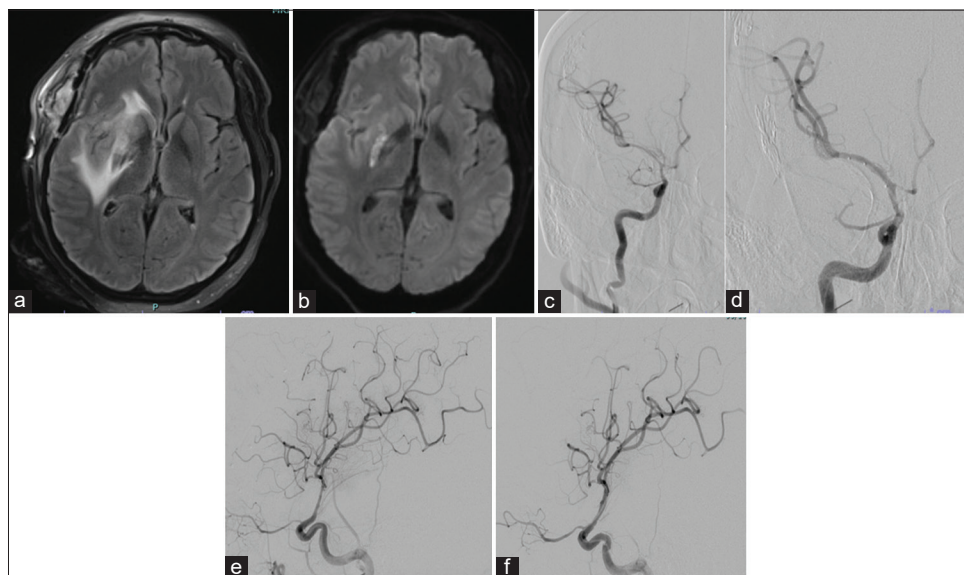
(a) FLAIR magnetic resonance imaging revealing stable perilesional edema on postoperative day 8. (b) Diffusion-weighted imaging showcasing a right posterior limb of the internal capsule acute infarct. (c-f) Cerebral angiographic images of the anterior circulation displaying moderate vasospasm in the right supraclinoid internal carotid artery (ICA), the carotid terminus, A1 of the anterior cerebral artery, and M1 of the middle cerebral artery (MCA). (e and f) Improvement in caliber and diameter of supraclinoid ICA and MCA after angioplasty and intra-arterial injection of nicardipine.
